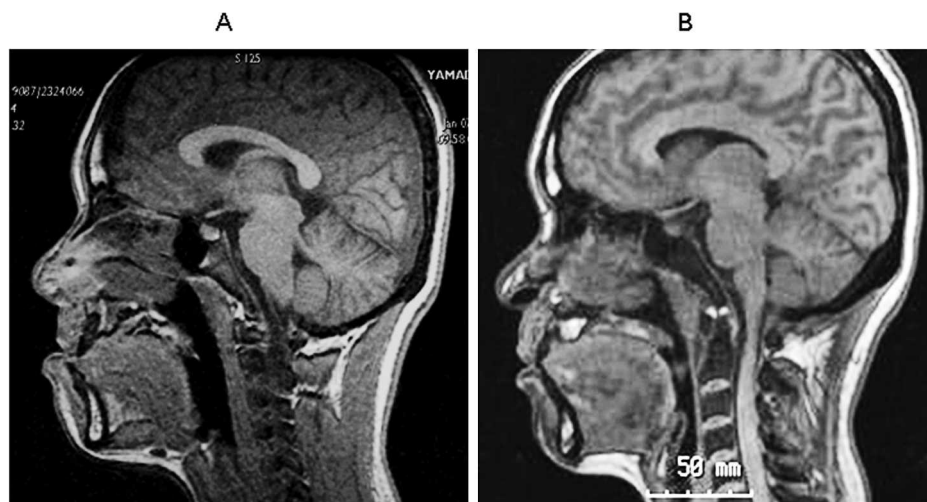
Magnetic resonance imaging (MRI). (A) Pretreatment (17 years 11 months). (B) 1 year after treatment (21 years 1 month).
